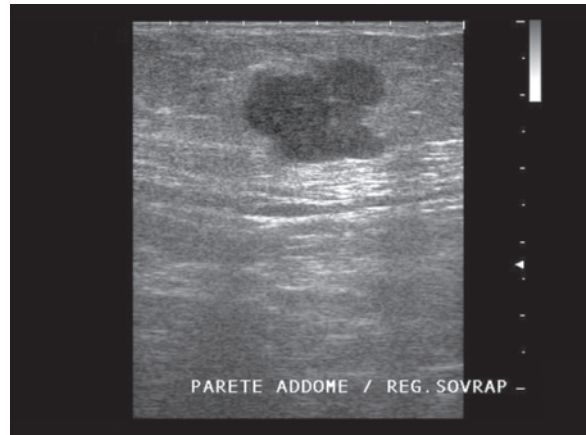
b Metastasis of the abdominal wall from melanoma in a patient operated on in that site. Two deep subcutaneous hypoechoic nodules can be discerned immediately superficial to the muscle plane which appears atrophic (a). Three other nodules were present but only the larger two could be identified by CT (b, arrows)
